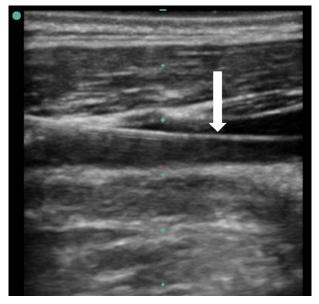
Longitudinal ultrasound of the internal jugular vein demonstrating the guide wire (arrow) within the lumen of the vessel.
